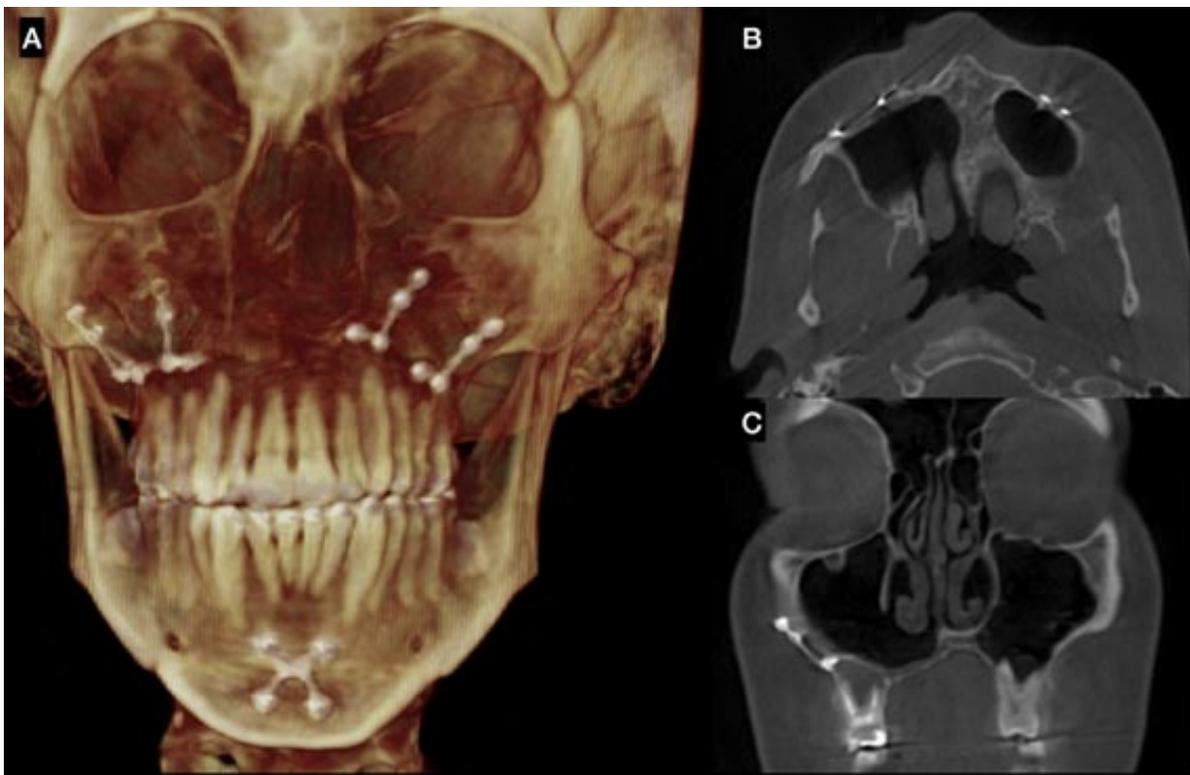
CT 5 year after surgery. A) 3D reconstruction showing stability of new bone position and fixation. B) Axial section with no evidence of recurrence and good function of the maxillary sinus. C) Nasal and maxillary condition 5 year after surgery with a lower and lateral defect with no functional complications.
